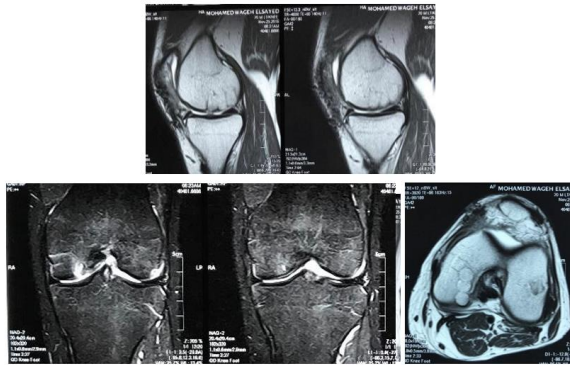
Postoperative MRI at 6-months follow up coronal, sagittal and axial views showing healing of donor site and healing recipient site and congruent articular surface and full incorporation of the graft at the recipient site.
